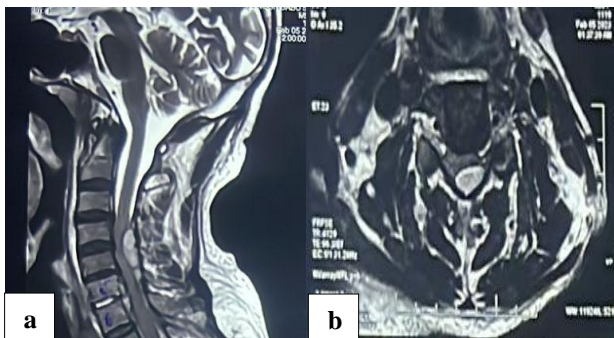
(a and b): Magnetic resonance imaging of the cervical spine was compatible with a diagnosis of infective spondylodiscitis at C5-6 with associated vertebral osteomyelitis and epidural abscess posteriorly characterized by low signal intensity on T1-weighted image and high signal intensity on T2-weighted image.
